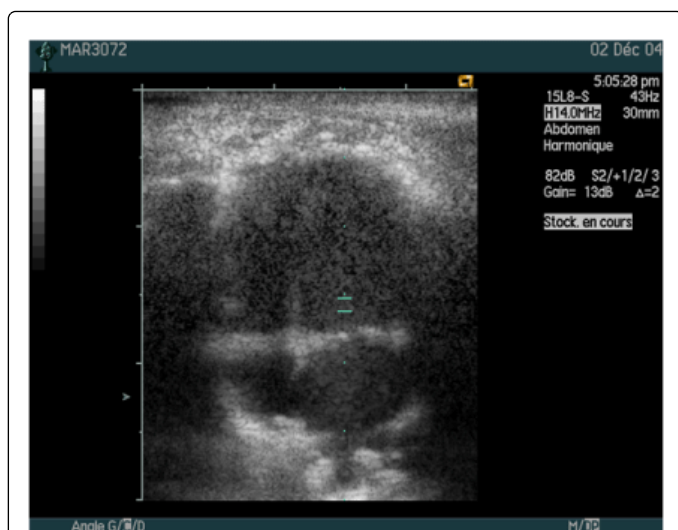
Two dimensional echocardiography in marmoset. Four cavity section in apical incidence showing the different cardiac structures and positioning of the Doppler guidance line for recording mitral flow. LV: Left Ventricle; RV: Right Ventricle; LA: Left Atrium; RA: Right Atrium.
